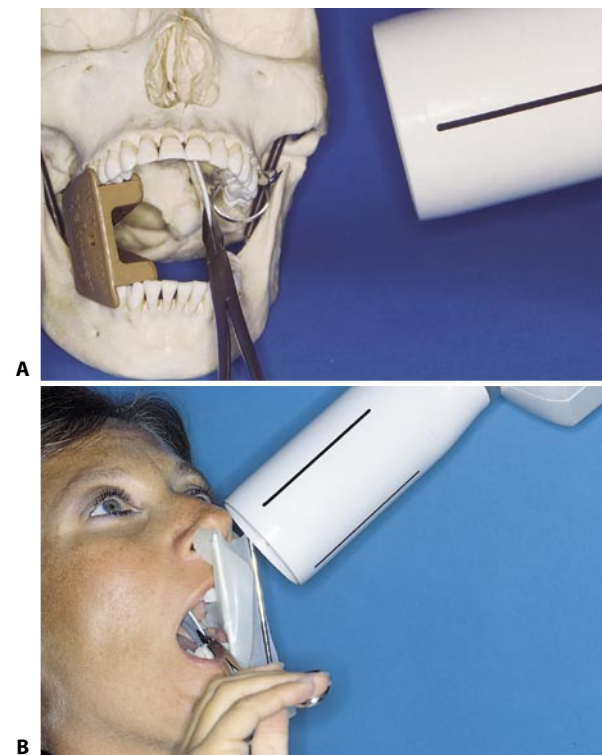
Intraoperative radiograph of the upper molars. A. The long side of the radiograph is aligned along the median line of the palate. B. To keep the radiograph more firmly in position, the patient may hold Steiglitz's forceps against the lower incisors.
